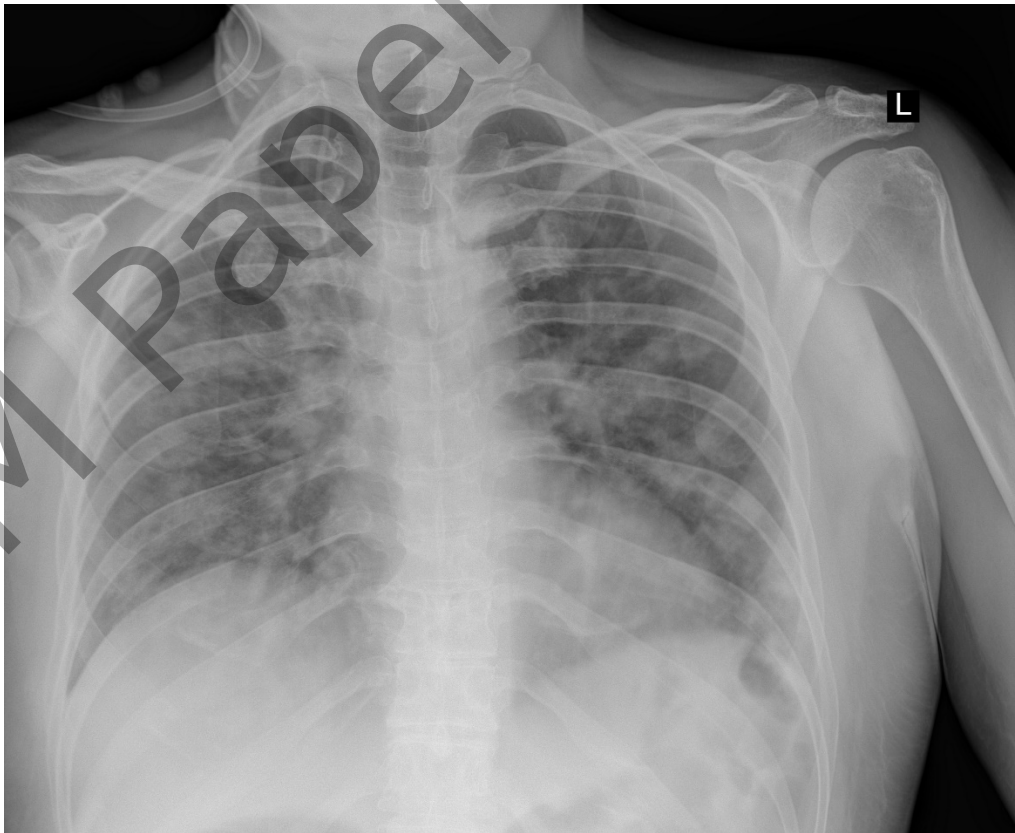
X-ray on the third day of tocilizumab therapy
